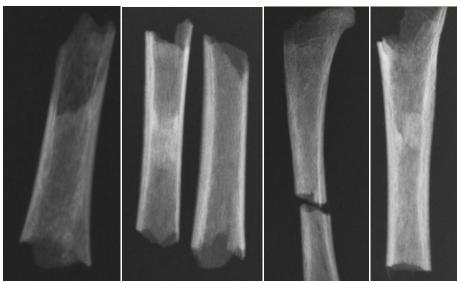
v. - Radiographs of periosteal cloaking. The double layer of cortical bone is clearly visible. (from left to right: CR86s7, s9, s5, s17, s16)
